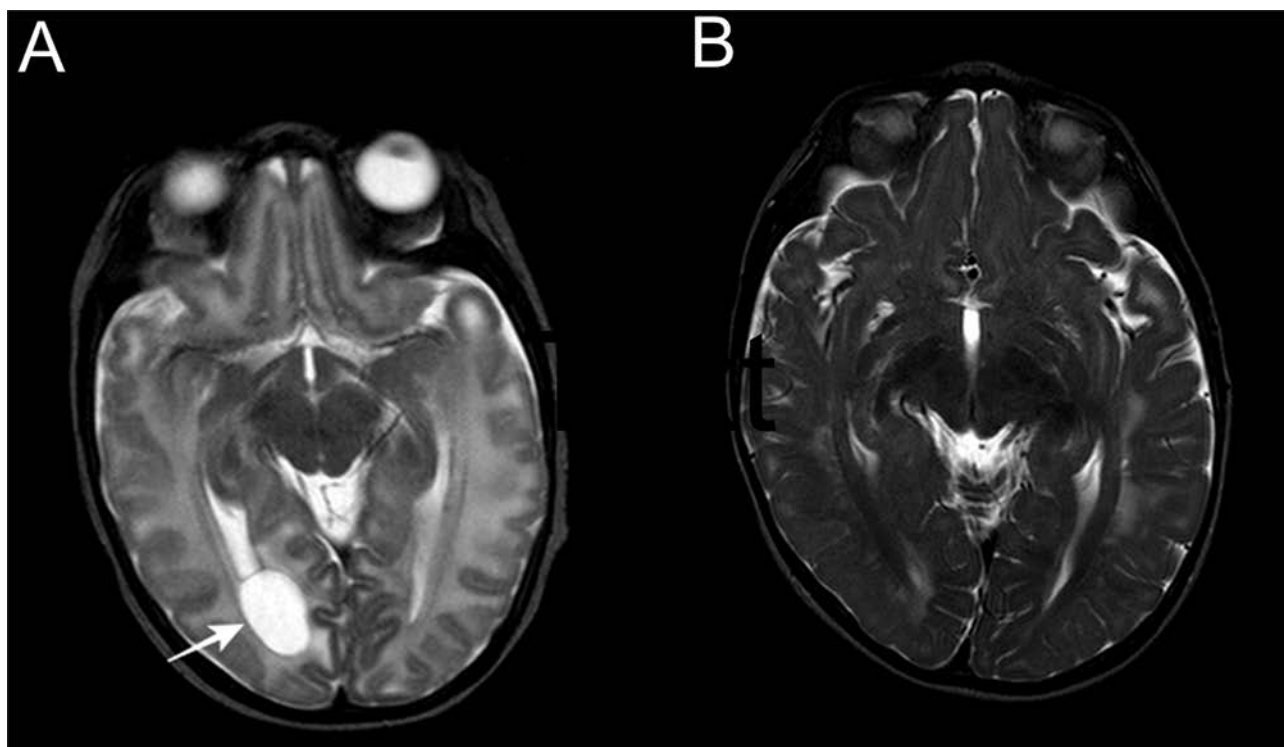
MRI brain scan: a) cystic lesion (arrow) (max. diameter 12 mm) in the right temporal pole, very close to the temporal horn of the right ventricle; b) one year later, the absence of the lesion can be noted.
